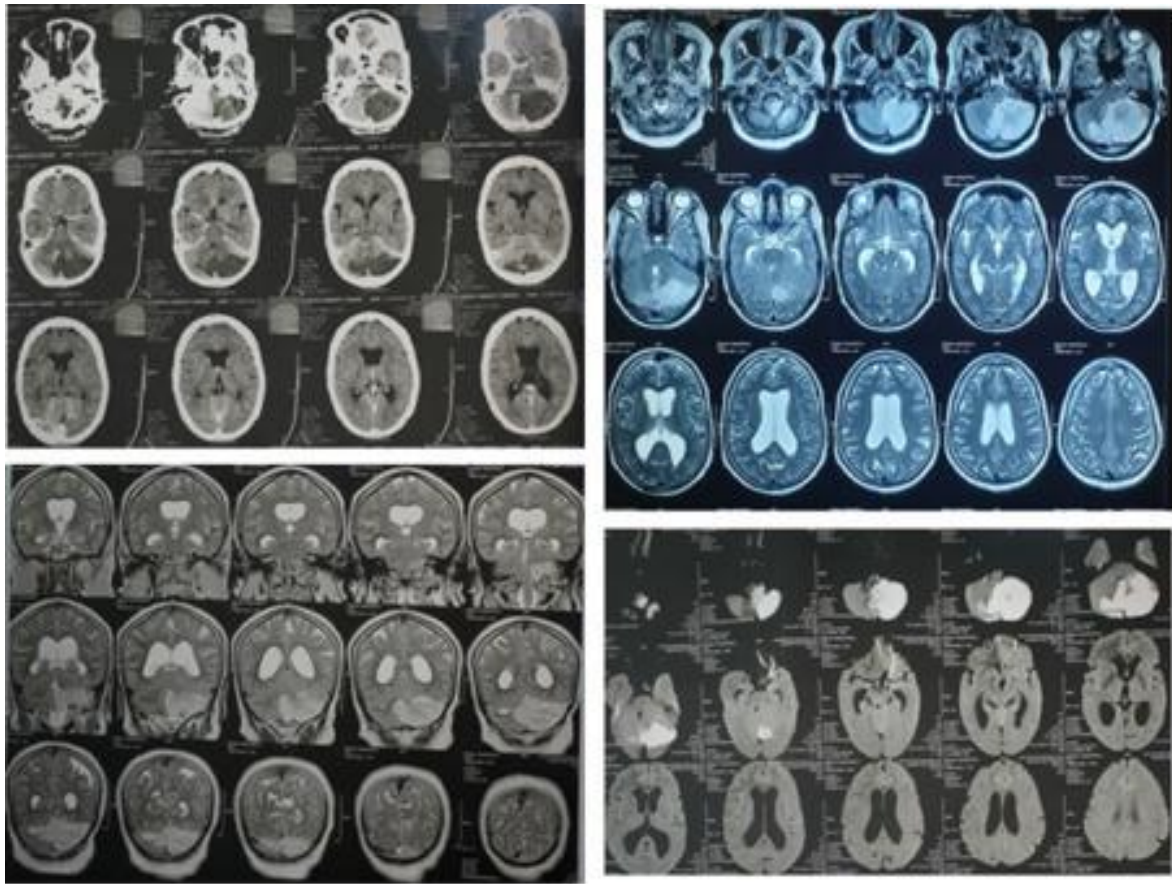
A: Preoperative CT and MRI scans of Case 3.
